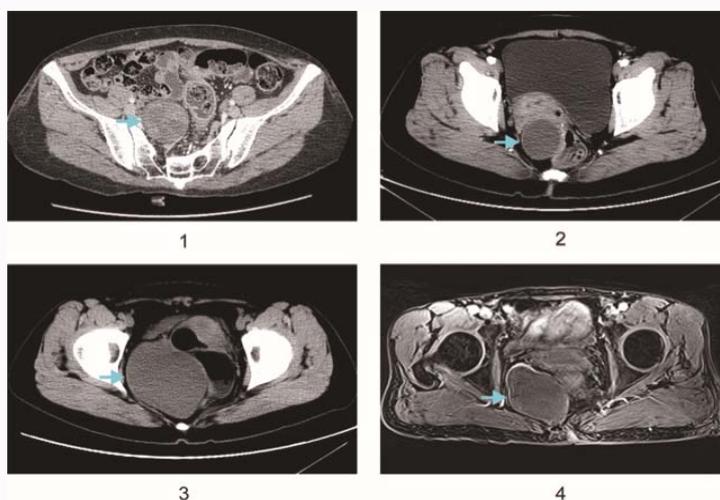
The horizontal images of benign presacral tumors on CT/MRI. The tumors are marked by the blue arrows.
